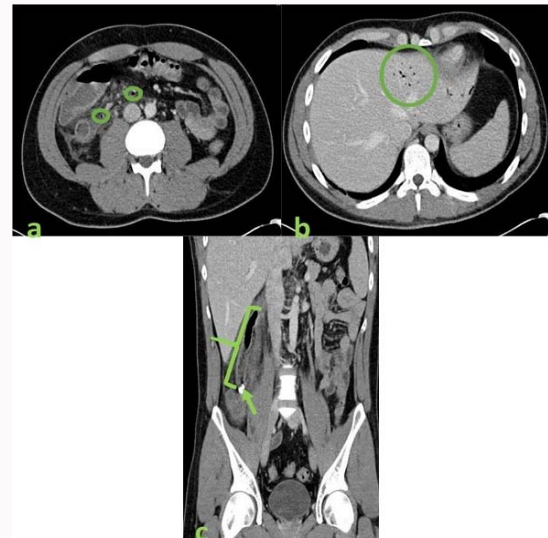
Salient CT-Scan findings at admission: (A) Free air in the abdomen (small circles). (B) Pneumobilia in the left liver lobe (circle). (C) Swollen, inflamed, ca. 15 cm long appendix ascending cranially and medially towards the liver containing an appendicolith (arrow) consistent with an acute perforated appendicitis.
